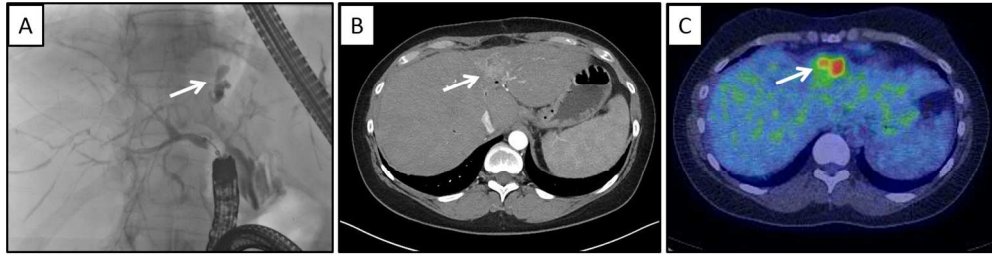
Cholangiocarcinoma (CCA) in a 51 year old asymptomatic female with primary sclerosing cholangitis and an elevated CA 19-9. A: ERC, the white arrow demonstrated segmental bile duct obstruction worrisome for CCA in this context; B: MRI, the white arrow denotes a mass lesion; C: Positron emission tomography, the white arrow demonstrates avid uptake of ^{18}F -FDG consistent with a malignancy
